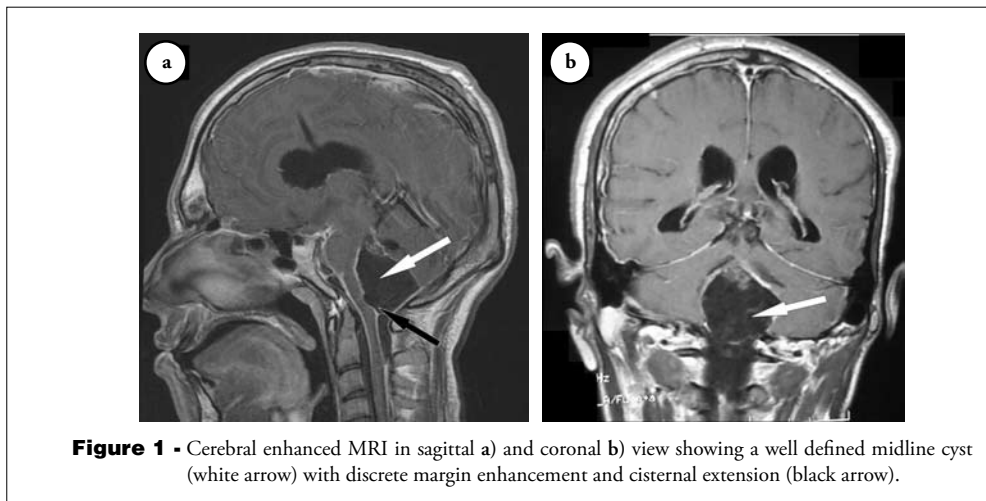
Cerebral enhanced MRI in sagittal a) and coronal b) view showing a well defined midline cyst (white arrow) with discrete margin enhancement and cisternal extension (black arrow).
